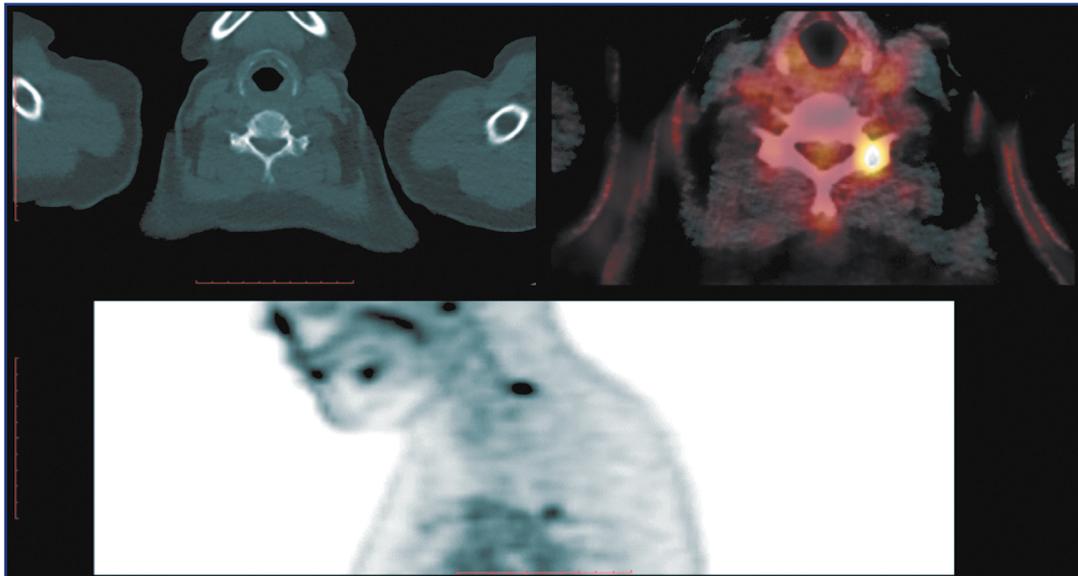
PET/CT. Metastasis in the arm of the C6 vertebra on the left.
